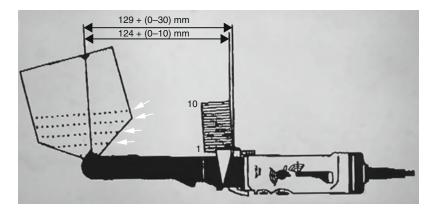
The ring connected to the ultrasound probe; this ring is perforated with longitudinal channels through which the probes are introduced (*white arrows*) (Adapted with permission from Zlotta AR, Djavan B, Maton C.
